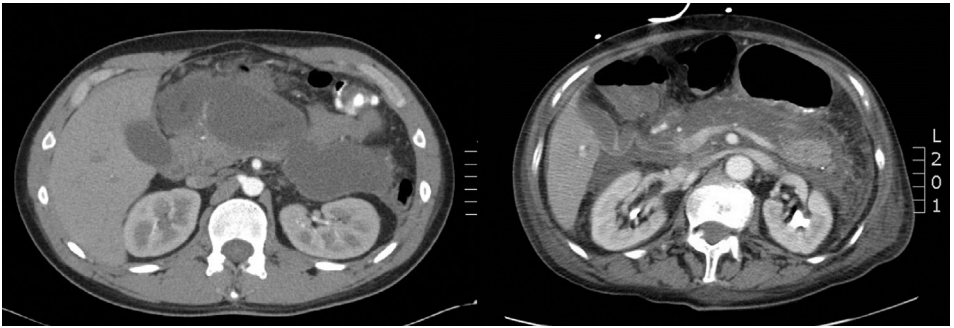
Enhanced CT scan shows acute necrotic collections.
